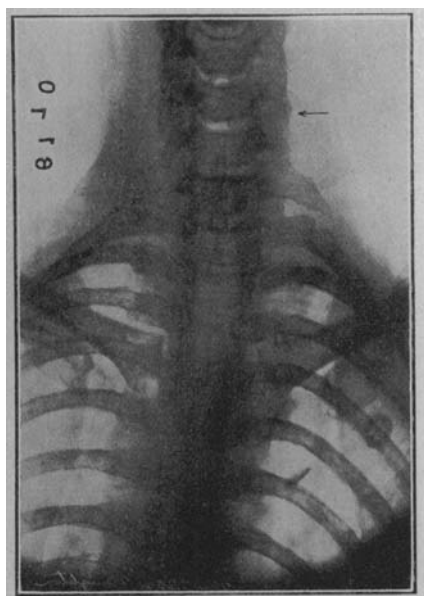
Radiograph of same patient. The piece of bone, though present at the level of the dart, does not show. An example of the misleading negative radiograph, and an indication for lateral as well as antero-posterior radiography.
